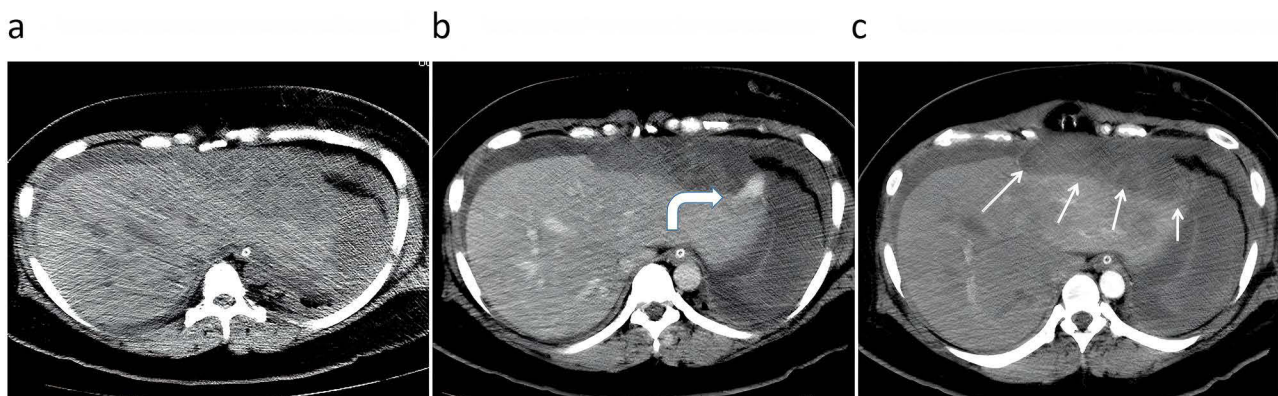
Postoperative CT scan of the upper abdomen after hepatic rupture repair. (a) Non-contrast CT image at the same level; (b) Enhanced CT image showing contrast extravasation (curved arrow); (c) Subcapsular hematoma (white arrow).
